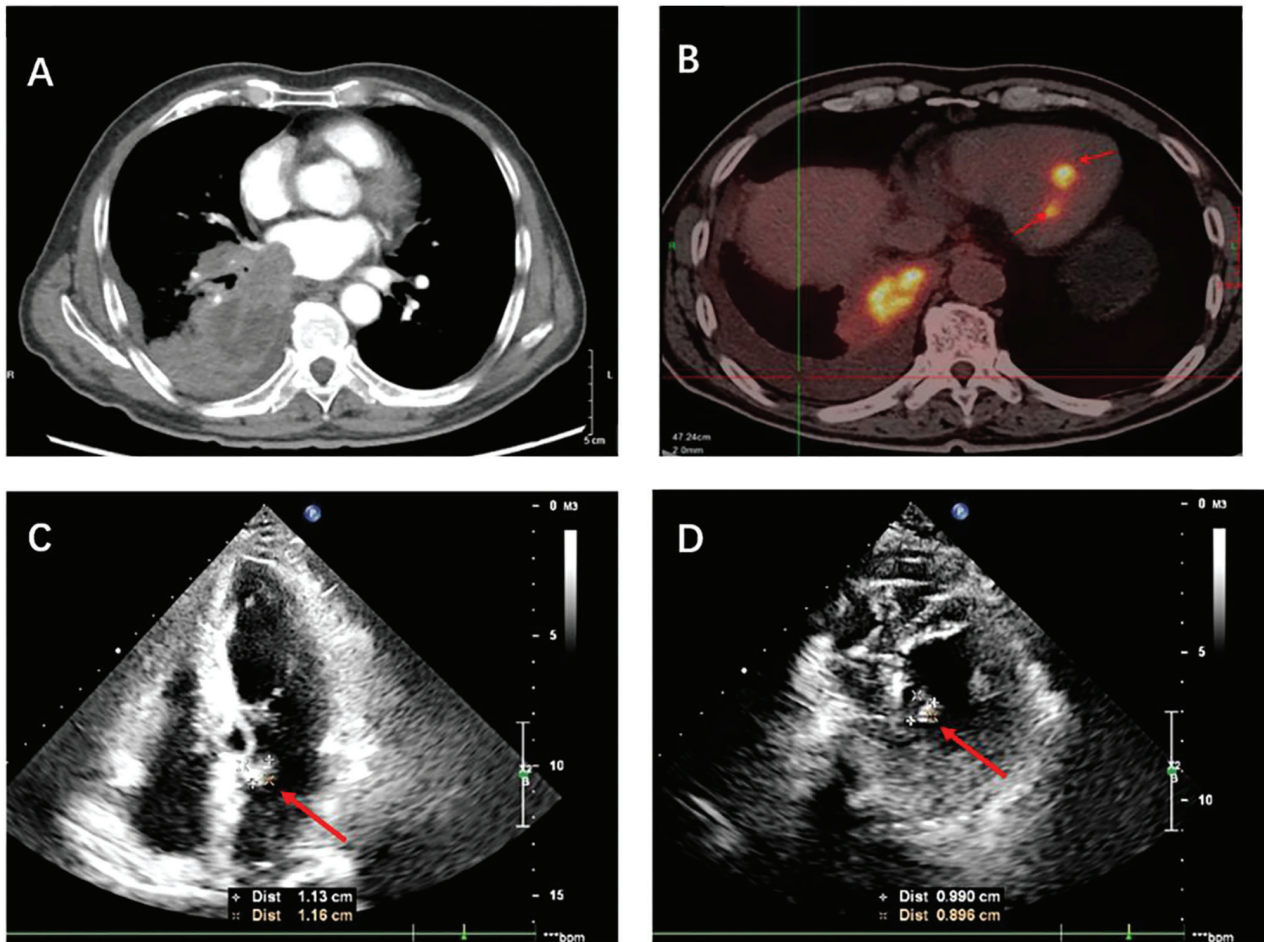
Perihilar and cardiac masses before treatment. (A) Chest CT shows a 10.5x7.6-cm parahilar mass in the lower lobe of the right lung, invading the pulmonary arteriovenous mass and left atrium. (B) Positron emission tomography/CT scan shows two radioactive concentrations of foci in the left heart chamber, with maximum standard uptake values of 8.9 and 6.3. (C) Transthoracic echocardiography shows an echogenic mass measuring ~1.1x1.2 cm attached to the atrial septum at the base of the proximal anterior mitral valve in the left atrium and (D) an echogenic mass measuring ~1.0x0.5 cm attached in the middle of the left ventricular posterior septum. CT, computed tomography.
